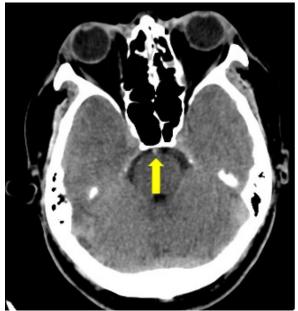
Computed tomography of brain showing hyperdense basilar artery sign (arrow)
